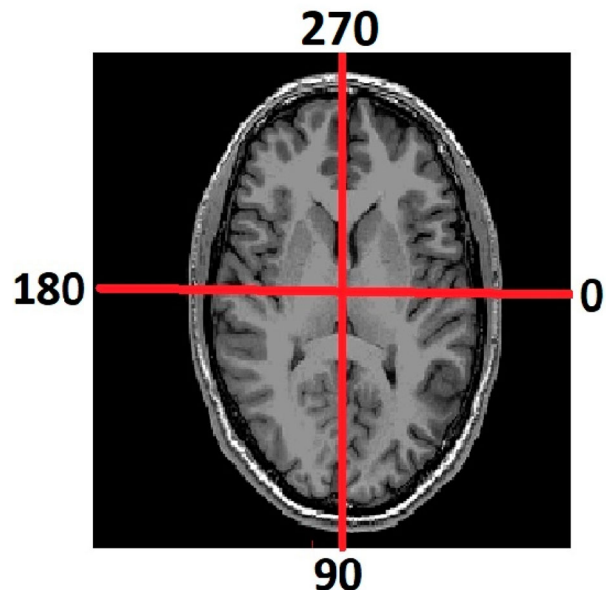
The red lines demarcate an MRI slice into four equal angular segments.
